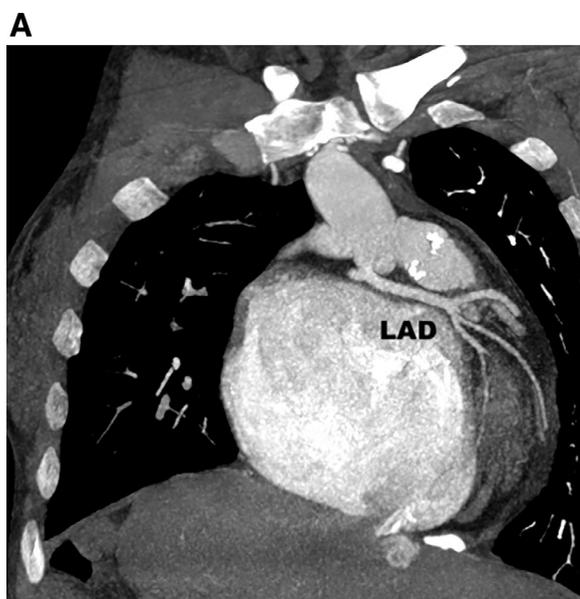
Single coronary artery (SCA) type Lipton R 2P. (A) Coronary computed tomography angiography, maximum intensity projection reconstruction, (B) volume-rendered reconstruction shows a SCA originating from the right sinus of Valsalva and dividing into the right coronary artery and left anterior descending artery. LAD=left anterior descending artery; LCx=left circumflex artery; RCA=right coronary artery.
